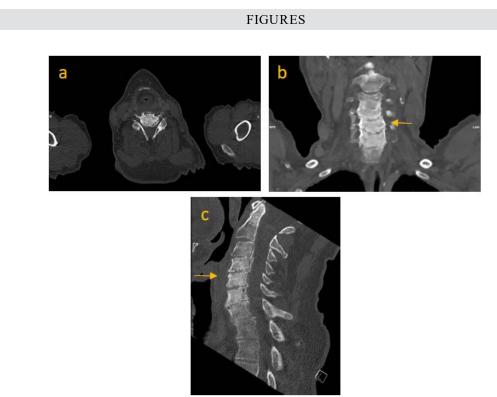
Computrized Tomography (CT) of vertebral column (a-c). Axial view at C5-level (a). Coronal view; C5 of the cervical spine is highlighted by an arrow. Accentuated extensive sclerosis of cervical vertebrae is detected.
